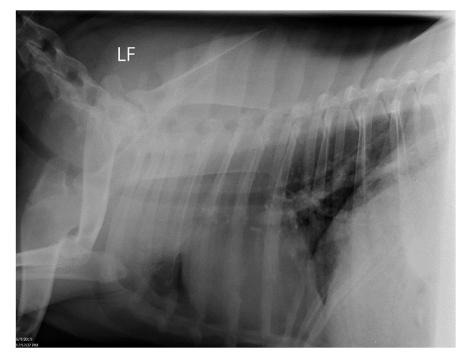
Repeat radiograph of thorax showing resolution of diffuse alveolar pattern, suggesting resolution of bronchopneumonia.
